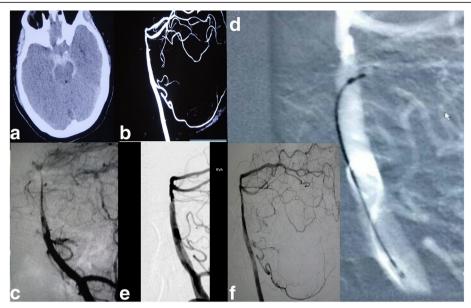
a-f. Case 2: A 51 year-old female patient presented with sudden severe headache and vomiting. CT scan (a) showed diffused subarachnoid haemorrhage. CT angiography (b) and Digital Subtraction Angiography (c) performed 8 and 10 days after the ictus, showed a small aneurysm arising from the proximal portion of a perforating vessel of the rostral basilar artery. Lateral projection of left vertebral artery (d) showed Echelon-10 failed to enter the aneurysm. Immediate DSA (e) showed no persistent filling of the aneurysm. Repeat DSA 36 days later (f) showed no persistent filling of the aneurysm and no parent artery compromise
